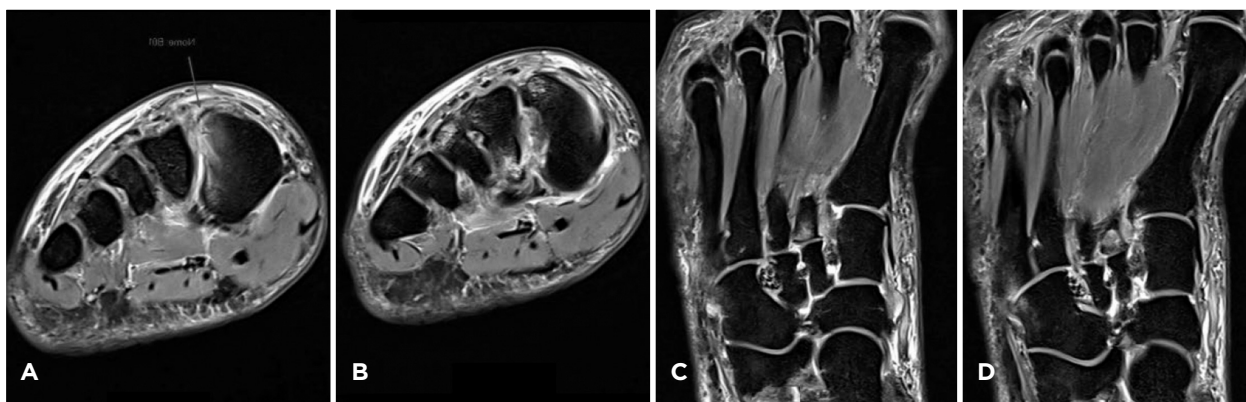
Initial magnetic resonance imaging of the edema and the Lisfranc ligament injury.
